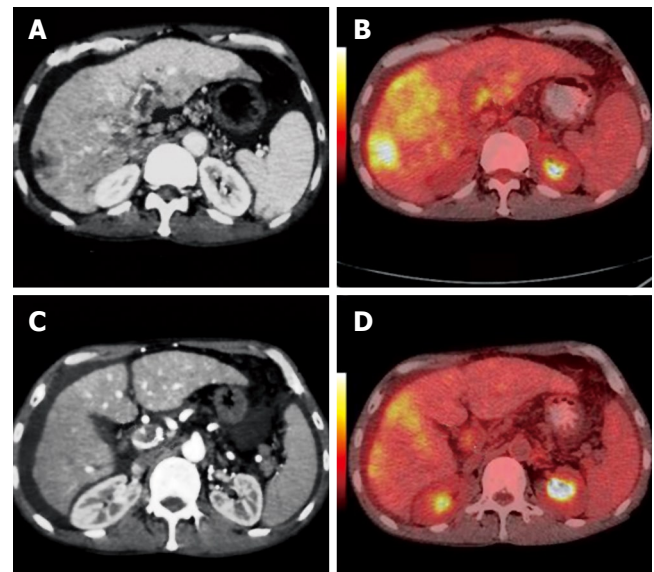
Contrast CT scan showing a diffuse tumor and portal vein thrombus in a 44-year-old man. During the arterial phase, the thrombus appears as a hypodense intraluminal area with mild enhancement at the LV (white arrows, A) and PV (white arrows, C). PET/CT fused images reveal a highly metabolic mass and a highly metabolic thrombus at the LV and PV, respectively (white arrows, B, D).
